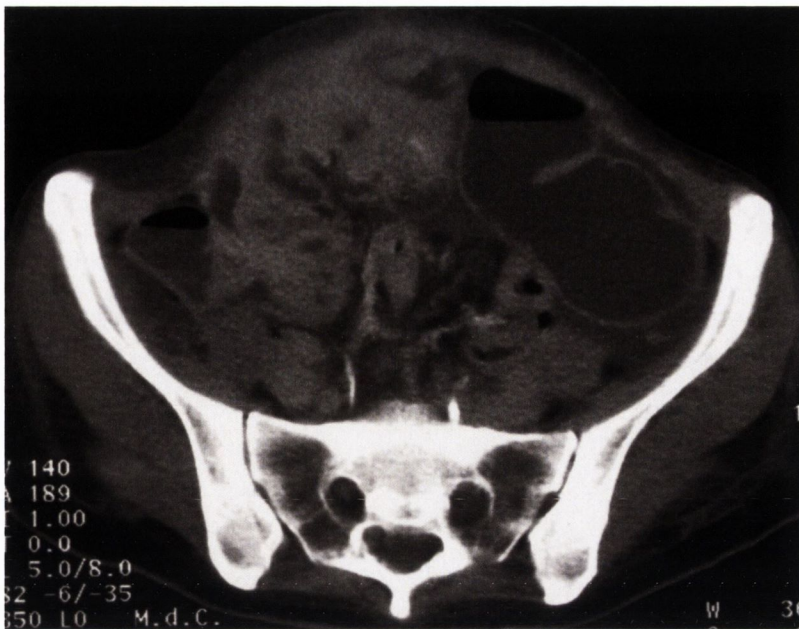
Computed Tomography Scan of Advanced Ovarian Cancer.
